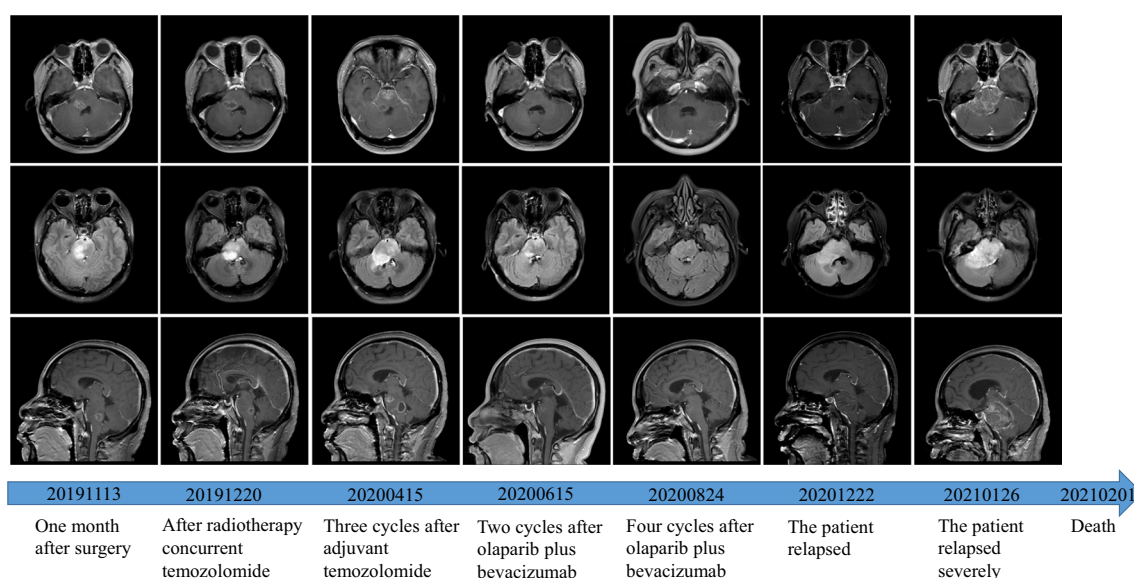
Timeline of the patient's postoperative treatments and changes observed in the brain magnetic resonance imaging during treatments
